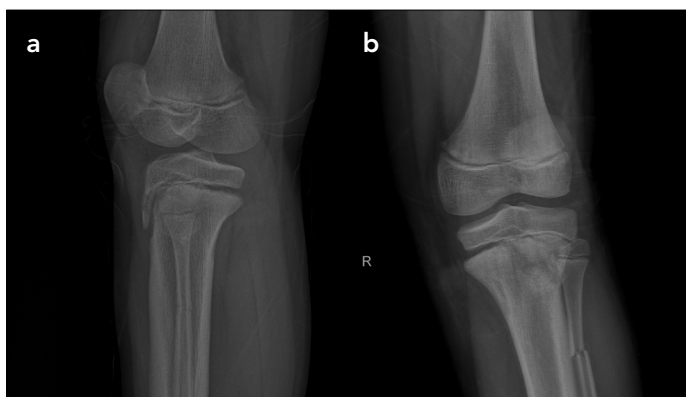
a, b. Direct radiography of the second case after trauma
